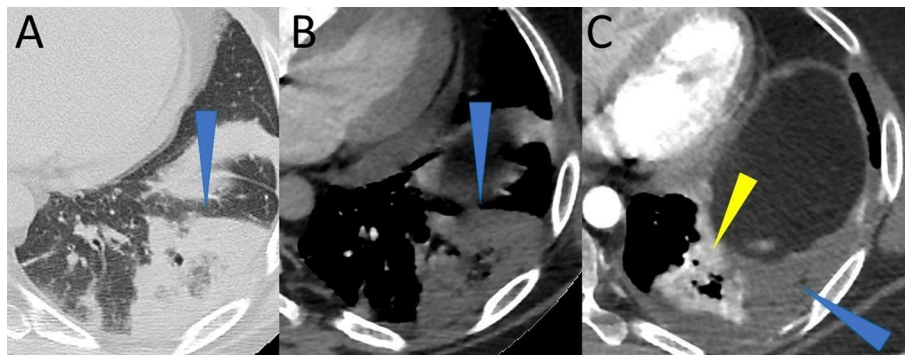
Axial CT images with parenchymal (A) and mediastinal (B and C) settings. RHS (blue arrowhead in A, B, and C) represents pulmonary infarction. The pulmonary infarction showed no enhancement after the contrast medium was introduced (blue arrowhead in B and C). At the same time, the neighbouring parenchyma with partial and lamellar atelectasis is vascularized (yellow arrowhead in C)
